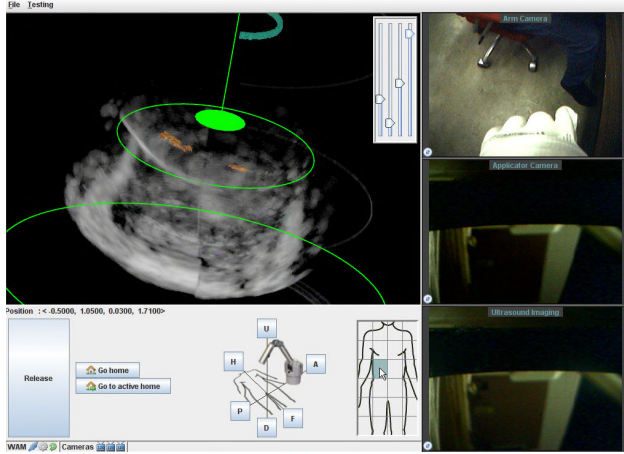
Remote operator control interface. The top left panel provides Doppler imaging data and an interface for treatment planning. On the right are camera views at the point of treatment and around the LSTAT. On the bottom are movement controls for the manipulator arm.
